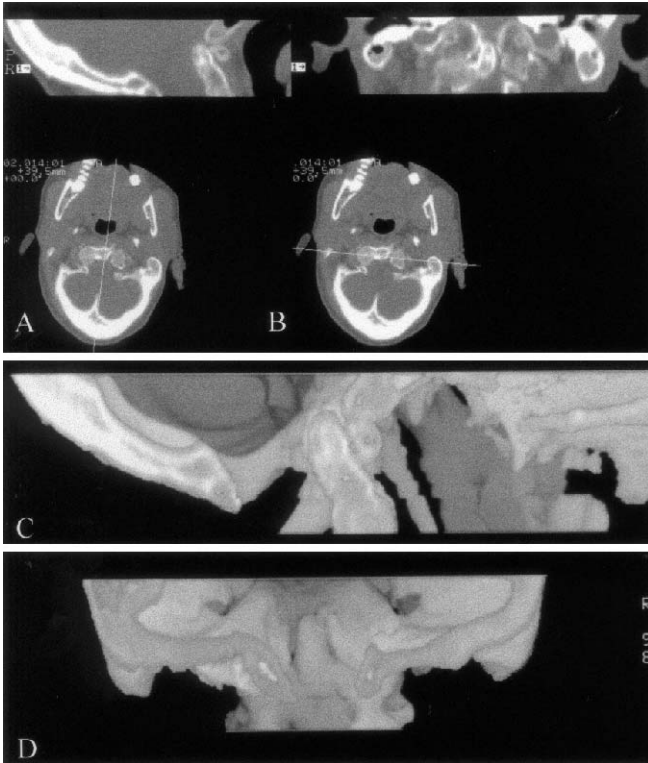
CT scan of the craniovertebral junction of a 9-year-old boy presenting with nuchal pain and mild head tilt. Axial CT scan through the craniovertebral junction with A lateral and B frontal reformatted images. C Reformatted midsagittal view, and three-dimensional CT views in the D midsagittal plane. Note partial atlas assimilation (*right lateral mass*) and mild cerebellar tonsil displacement into the cervical canal
